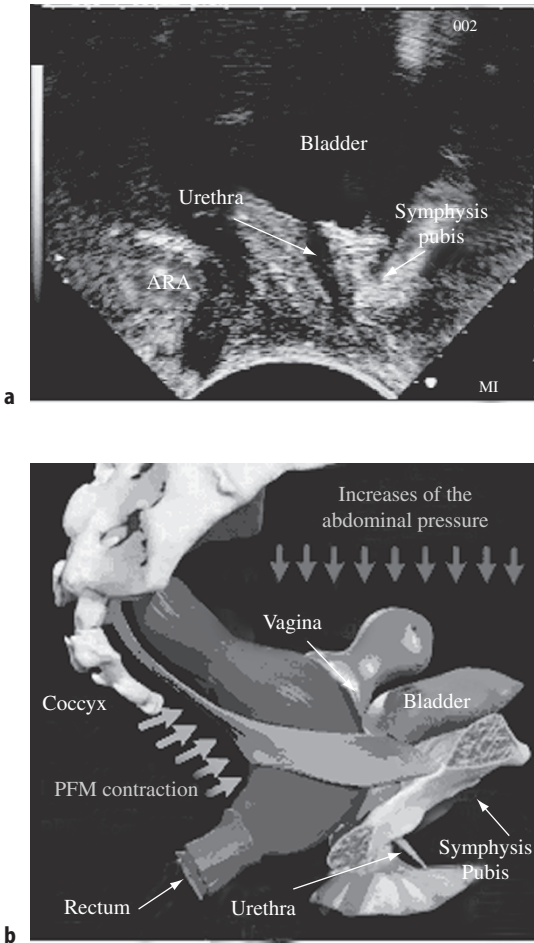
1. (a) Typical still image of perineal ultrasound frame at rest (anorectal angle, ARA). (b) This demonstrates how a PFM contraction will help prevent urinary incontinence. The continent PFM contracts in preparatory response to increased intra-abdominal pressure. (Copyright Primal Pictures Ltd. www.primalpictures.com)
